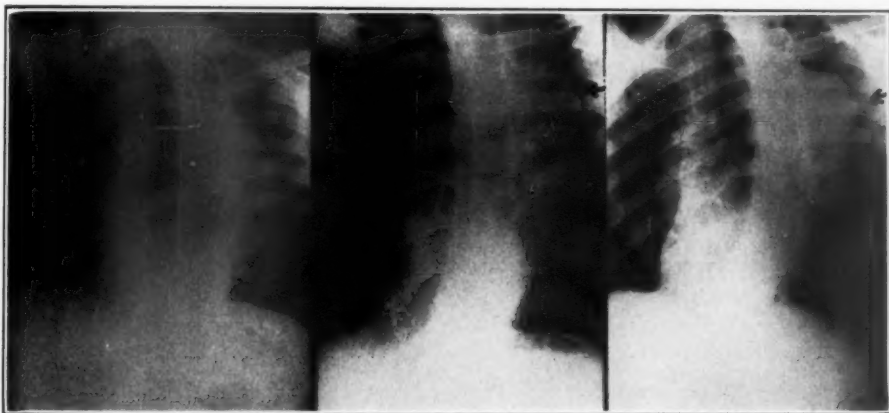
Roentgenograms taken in the right oblique position on first, thirty-first, and forty-third days of illness. Note the local bulge where the final rupture occurred.
